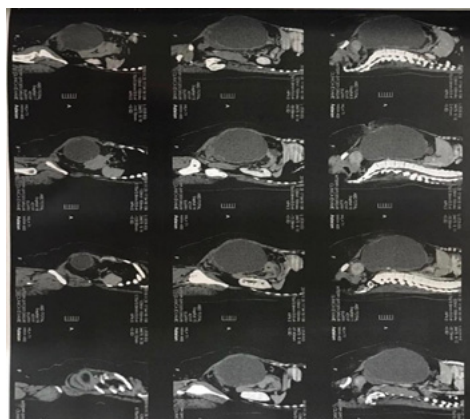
Sagittal Computed Tomography (CT) section of the abdomen – encapsulated liquid collection occupying the entire peritoneal cavity.
